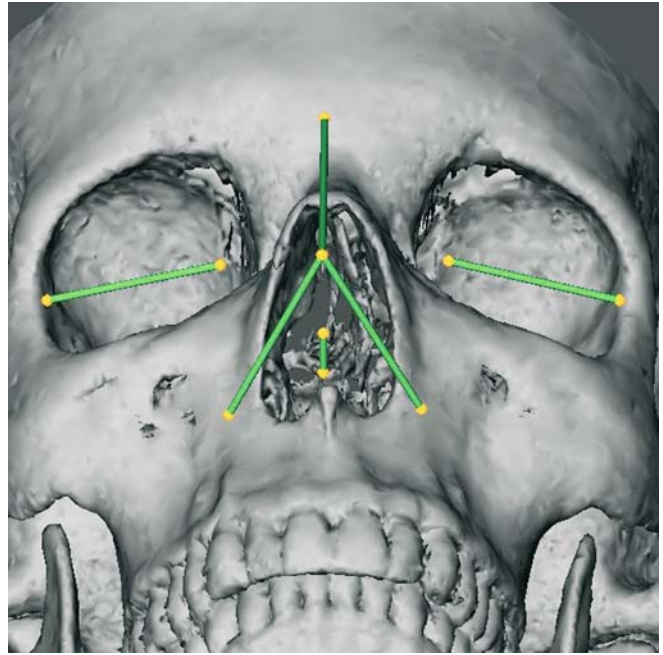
Superimposition of 3-D soft tissue distances on the hard tissue surface representation (3-D CT, patient K.C.)
